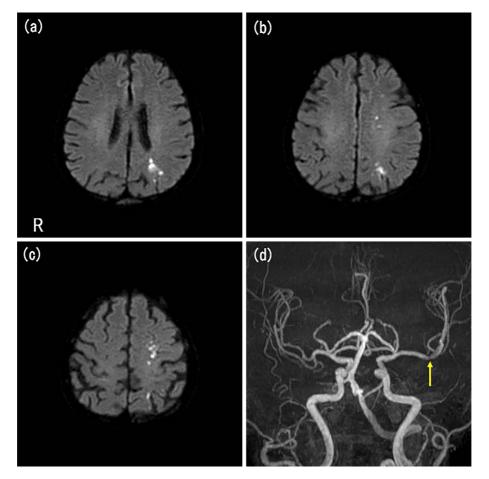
(a-c) Diffusion-weighted magnetic resonance imaging shows fresh infarction in the left hemispheric watershed territories (the first stroke). (d) Magnetic resonance angiography shows mild stenosis of the left middle cerebral artery (arrow).
